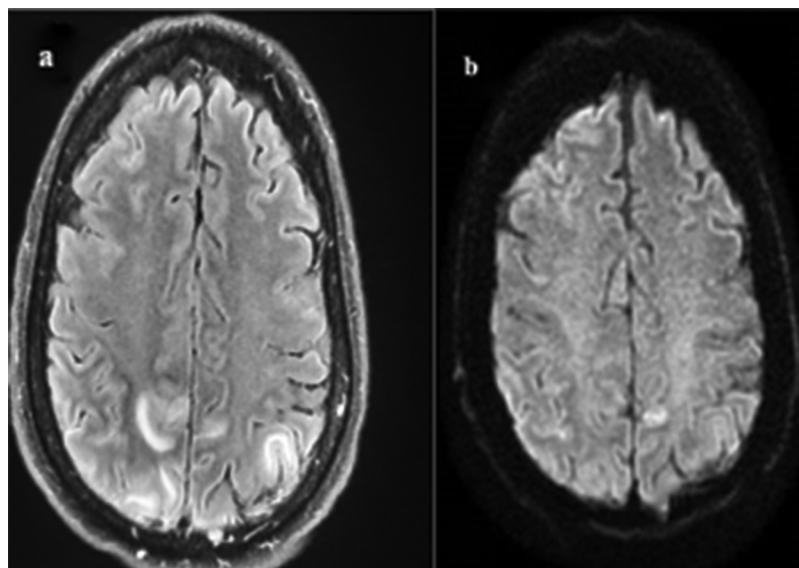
MRI of the brain, Axial view, revealing Posterior reversible encephalopathy syndrome. (a) T2 FLAIR: hyperintensity in the parietal lobes. (b) Diffusion-weighted sequence: diffusion restriction in the parietal lobes.
